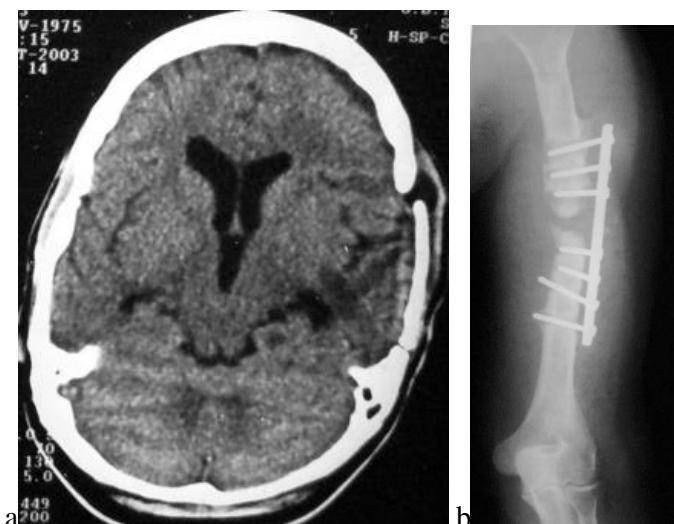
Complications of fracture. a. CT scan showing leptomeningeal cyst. b. Non-union in a patient who has undergone open reduction and internal fixation surgery.
